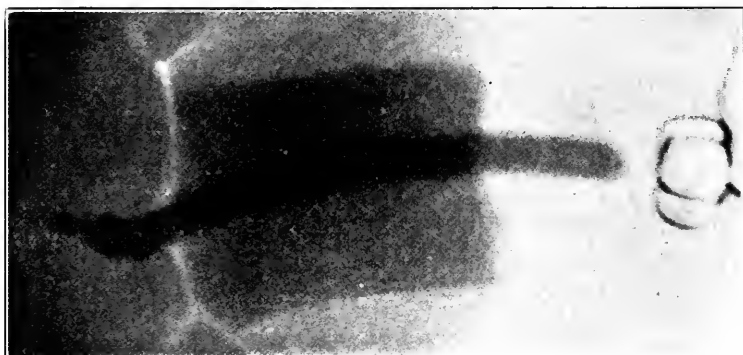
<sup>1</sup>—A filiform stricture in beginning of membranous urethra. X-ray of stricture with argyrol in urethra.
